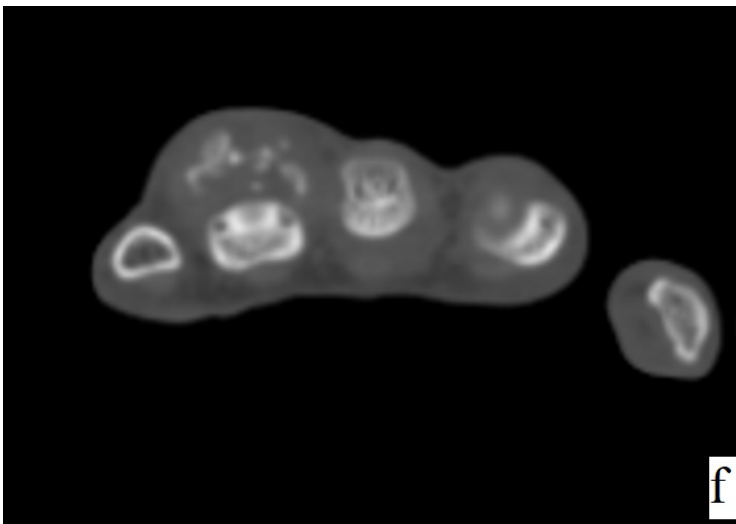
2D CT scan, an axial projection*
